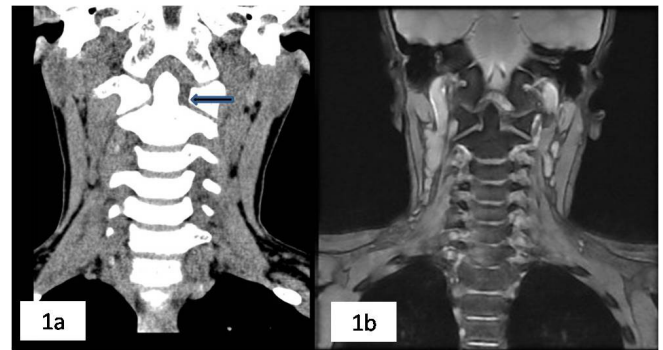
(a): Cor reformatted CT, (b): Cor T2W MRI images reveal laxity of the left alar ligament with increased atlanto-axial distance (arrow) owing to lateral subluxation at the atlanto-axial joint.
